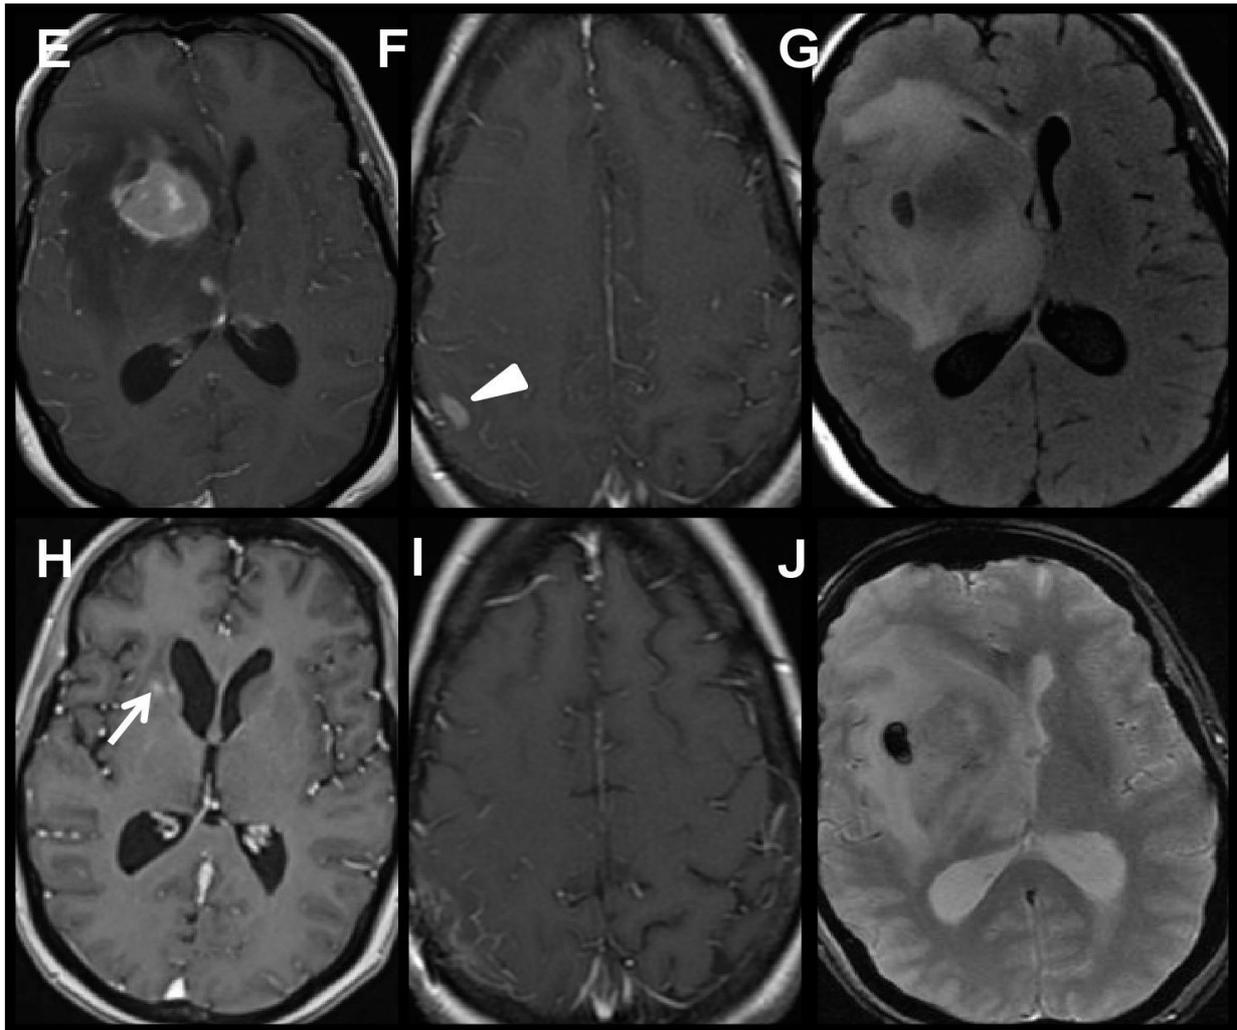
MRI brain seven months from initial presentation showing a large enhancing basal ganglia lesion (2.8 x 2.5 x 2.8 cm) with punctate foci of enhancement in right thalamus and caudate (E) connected to the basal ganglia lesion by FLAIR hyperintensity (G). There was also a superior ipsilateral enhancing parietal lobe lesion (F) and a contralateral FLAIR hyperintense non-enhancing left inferior frontal lesion. An uncharacteristic hemorrhage within the tumor bed is seen on gradient ECHO sequence (J). Partial response seen at 4 months after initiation of chemotherapy (H, I) with persistent contrast enhancement (arrow)
